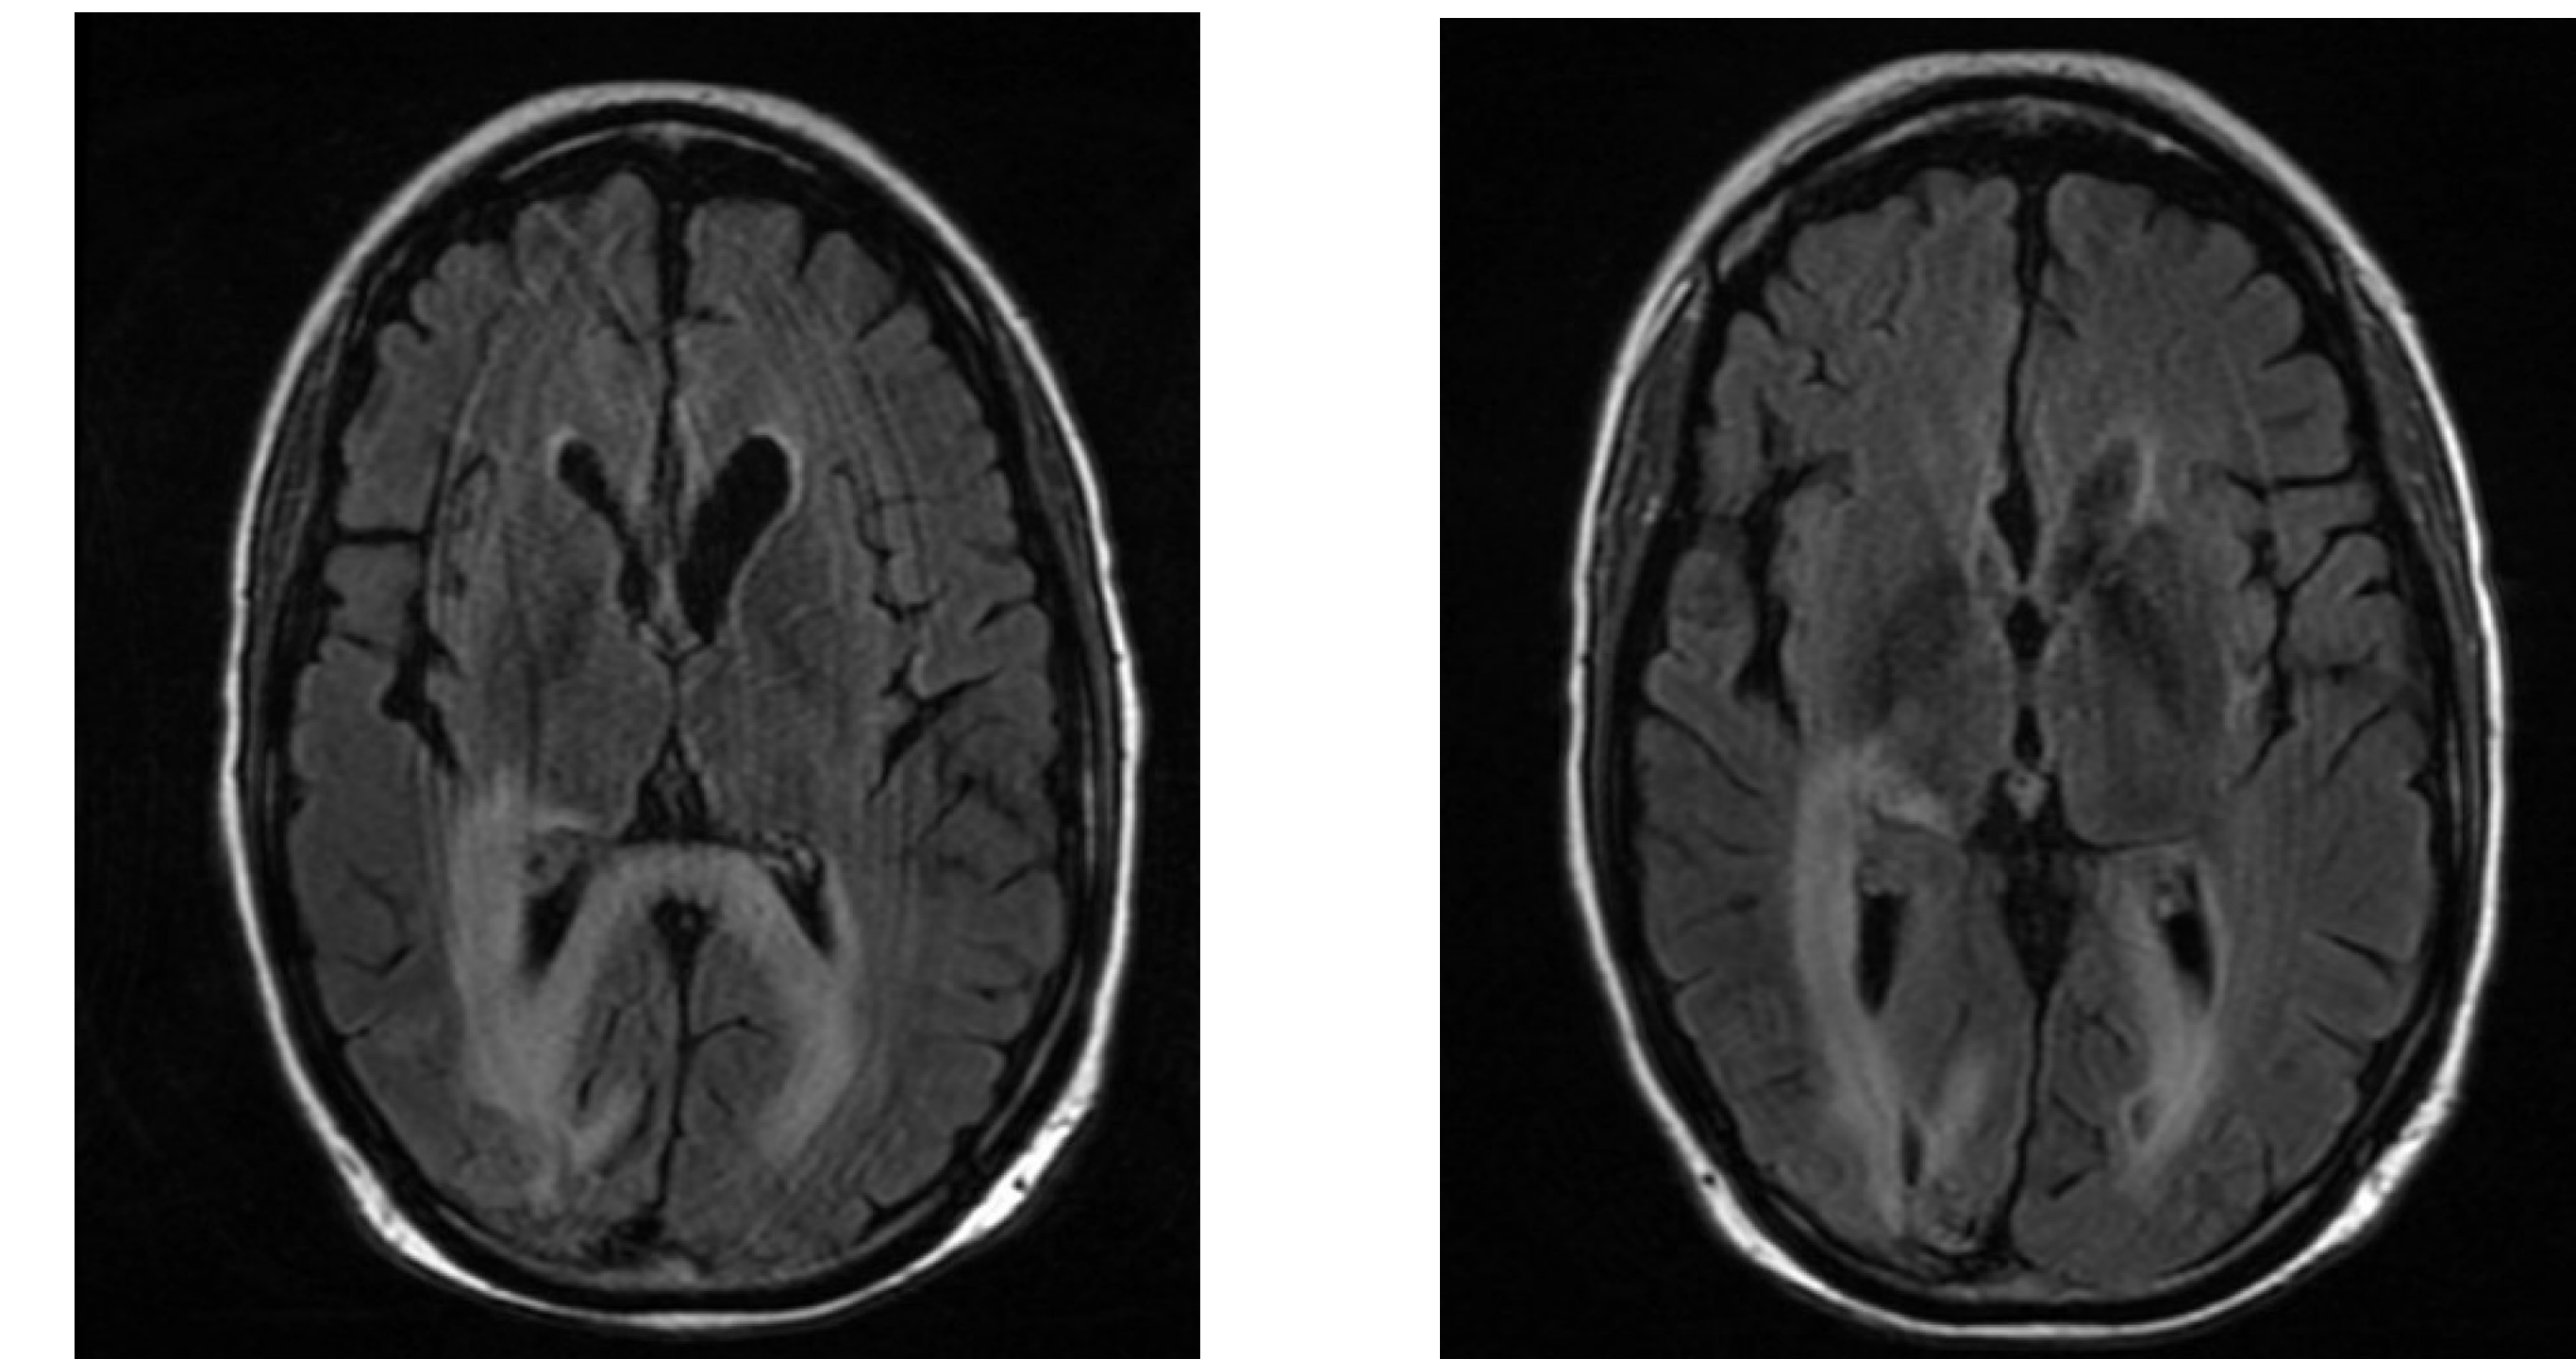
Brain Magnetic Resonance Imaging (MRI) – T2 Flair
